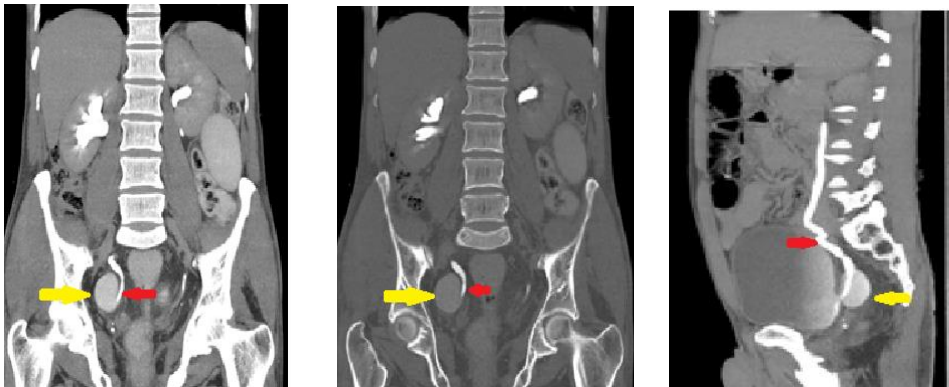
CT urography delayed maximum intensity projection coronal (a), (b) and sagittal (c) reformatted images revealing mild right hydroureteronephrosis. A well-defined saccular outpouching (yellow arrow) arising from the right posterolateral wall of urinary bladder is seen in the region of right vesico-ureteric junction. Mildly dilated contrast filled right ureter (red arrow) is traversing medial to the diverticulum.
